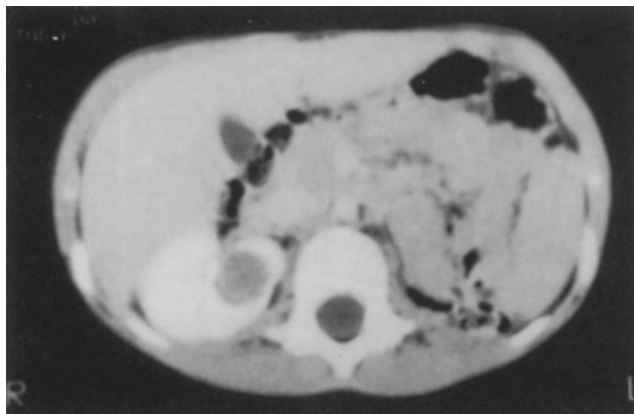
CT scan. The tumor is clearly seen as a non-opacified defect within the substance of the sole remaining (right) kidney.
